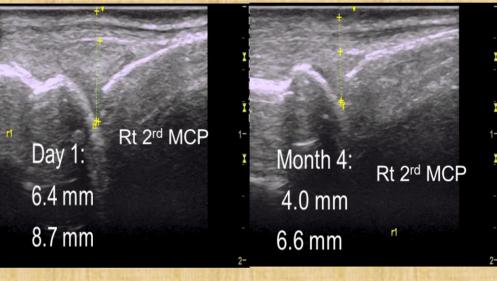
and 5 are grey scale ultrasound images which compares two of patient #6's MCP joints at Day 1 vs Month 4 of the PRTX105 trial. There is marked reduction of the distance from the base of the joint to the joint capsule surface (upper number) and the base of the joint to the surface of the digit (lower number).
